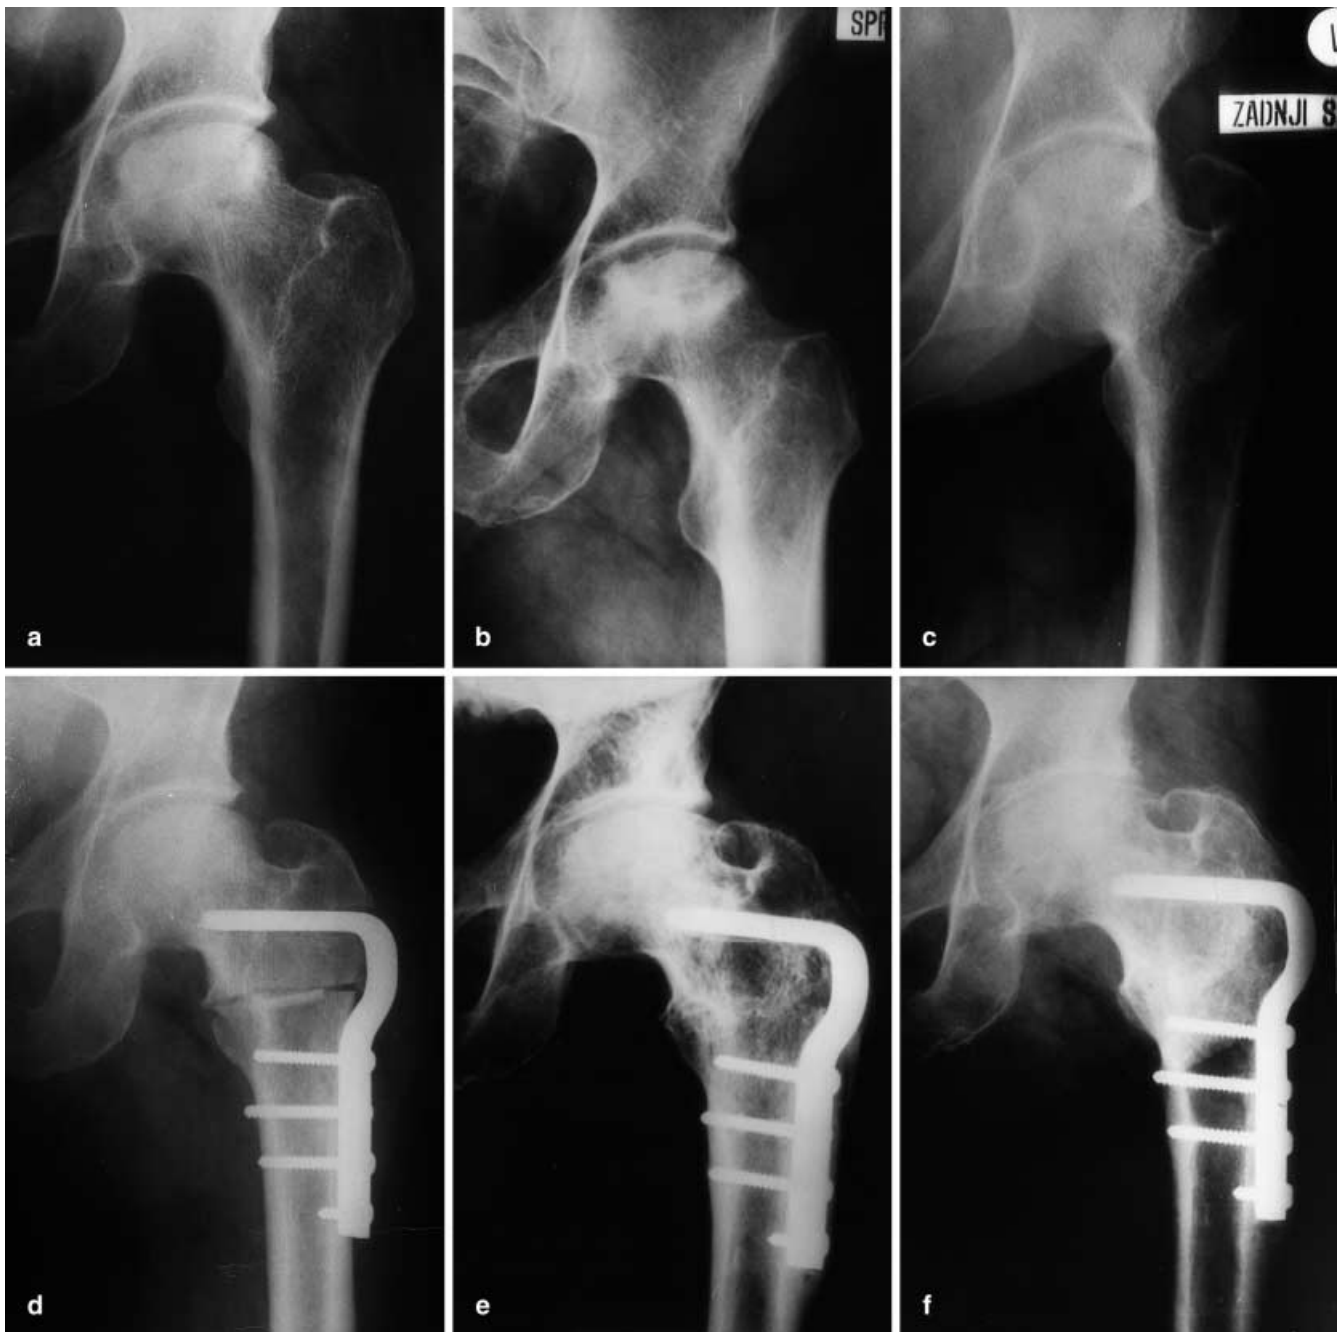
Preoperative radiographs of a 42-year-old man with Ficat stage III lesion of the left hip. a AP view. b Ventrocranial. c Dorsocranial segment of the femoral head. d AP radiograph after flexion osteotomy. e Nine years after primary surgery. f Fifteen years after primary surgery; slowly progressing
